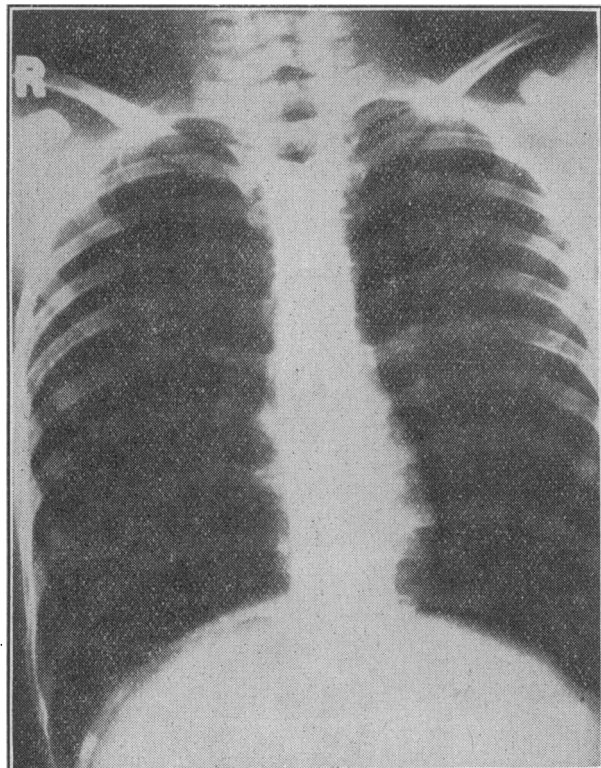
Case 1. Chest radiograph before treatment, showing a very small heart.
